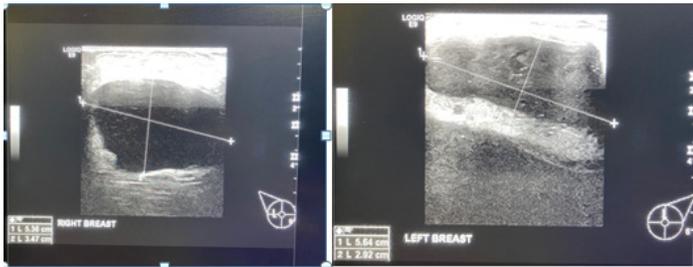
Followup ultrasound after 7 months showing no significant interval change
